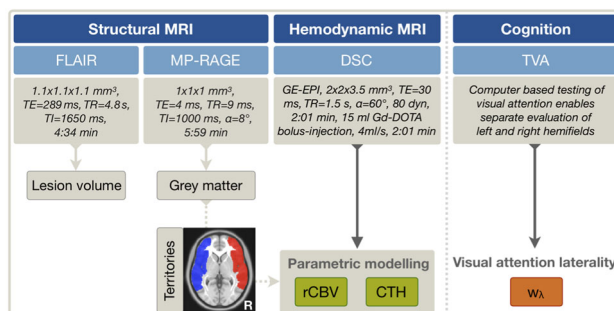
MRI protocol and cognitive testing. Lesion volume was segmented on FLAIR and grey matter masks on MP-RAGE. Relative cerebral blood volume (rCBV) and capillary transit-time heterogeneity (CTH) were derived by parametric DSC modelling. Lateralization of hemodynamic parameters (green) were compared in GM of MCA territories (blue & red). Besides, visual attention w_A was tested based on theory of visual attention (TVA, orange). All measurements were performed twice, in ICAS before and after treatment.
